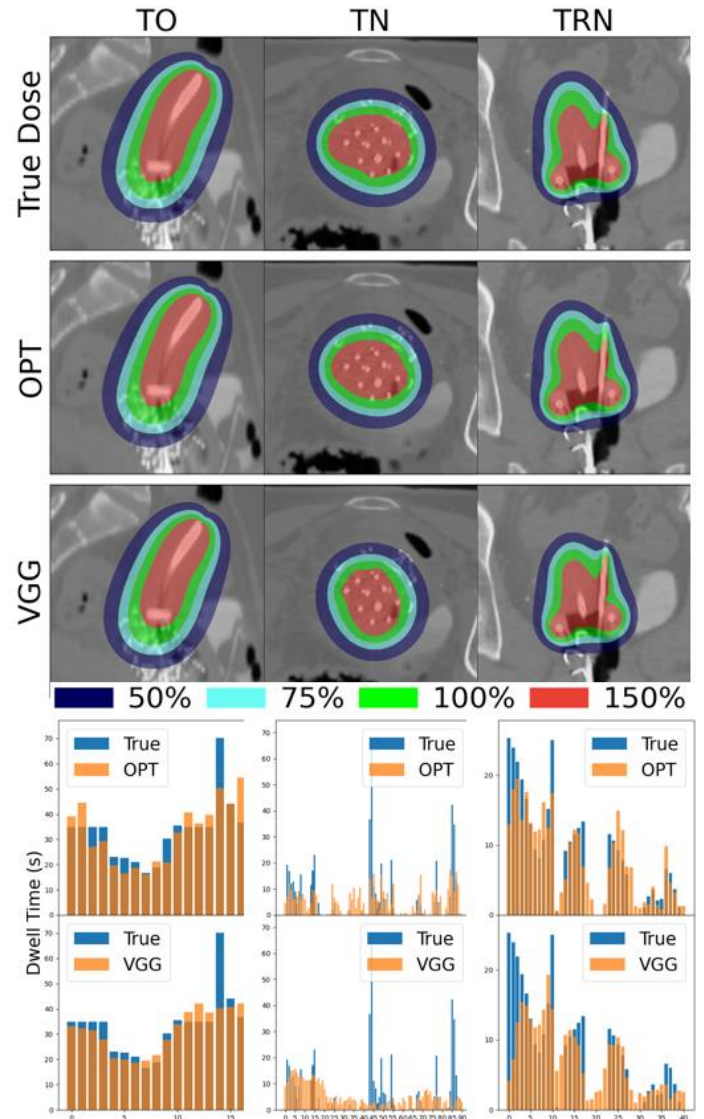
Comparison of dose distributions and dwell times for the two automated plans and clinical plan for three random patients. Isodose color washes (where 100% is the prescription dose) are overlaid over coronal (TRN), axial (TN), and sagittal (TO) CT images.
